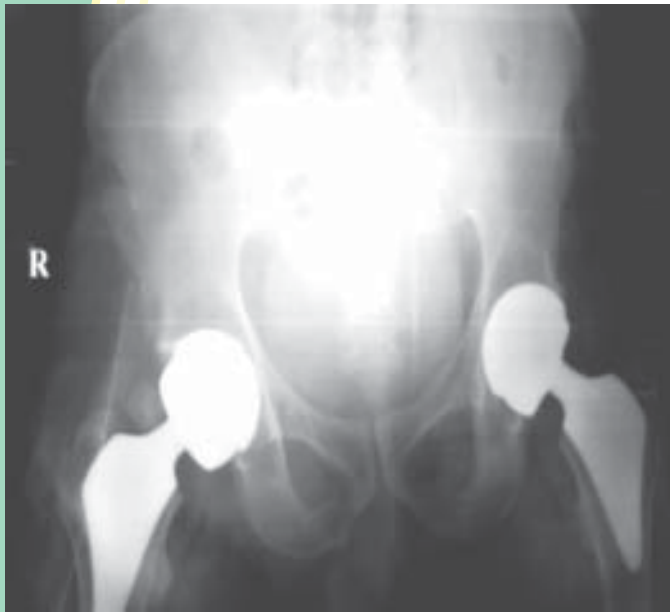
Postoperative X-ray after bilateral proxima hip replacement, on right side for comparison a standard uncemented hip is also shown.
